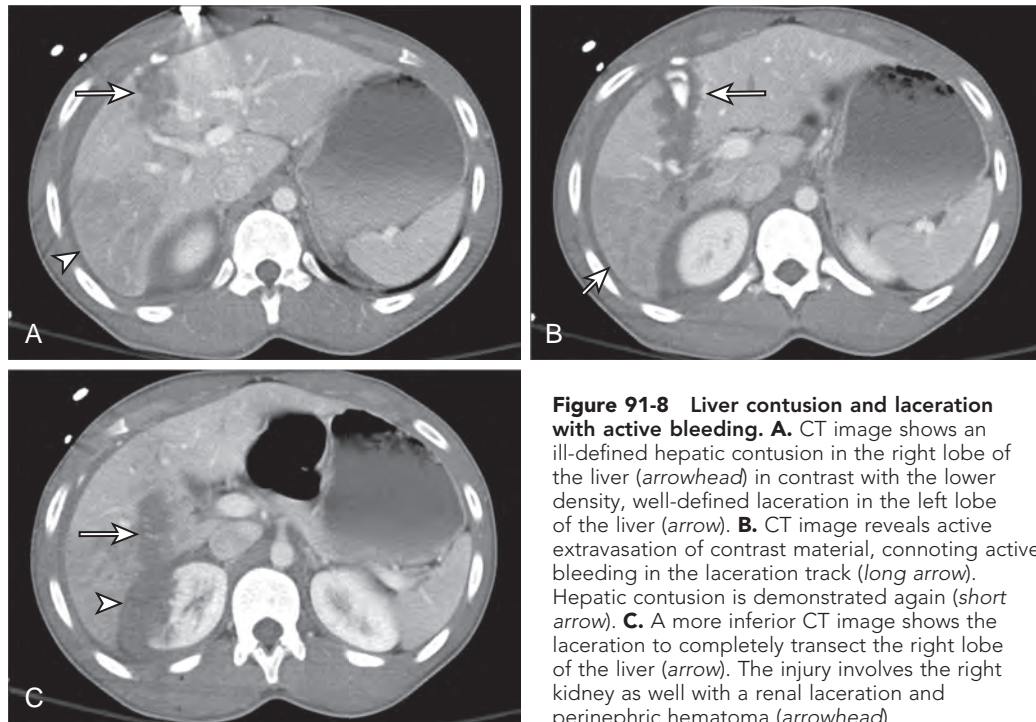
Liver contusion and laceration with active bleeding. A. CT image shows an ill-defined hepatic contusion in the right lobe of the liver (arrowhead) in contrast with the lower density, well-defined laceration in the left lobe of the liver (arrow). B. CT image reveals active extravasation of contrast material, connoting active bleeding in the laceration track (long arrow). Hepatic contusion is demonstrated again (short arrow). C. A more inferior CT image shows the laceration to completely transect the right lobe of the liver (arrow). The injury involves the right kidney as well with a renal laceration and perinephric hematoma (arrowhead).
